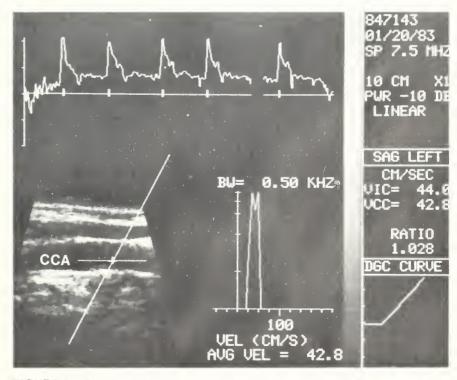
Longitudinal examination of a normal common carotid artery (CCA) in the "duplex" mode. The Doppler wave form tracing above occurs simultaneously with the real-time sonogram in the lower left corner. In the lower right corner is a histogram generated from the Doppler data of four cardiac cycles.
